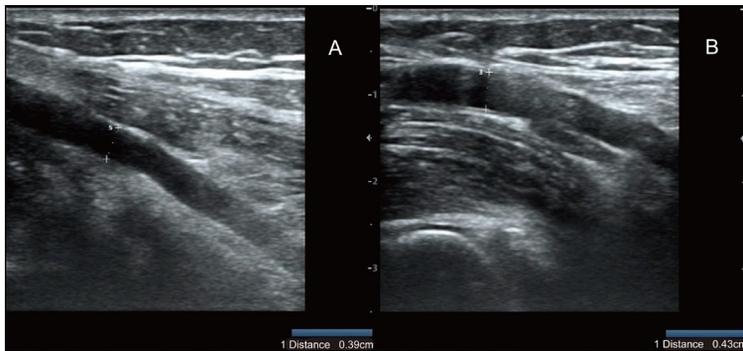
Typical Doppler images of the patient's brachial artery, with and without lymph node metastasis. (A) Doppler ultrasound image of the brachial artery in a patient without lymph node metastasis. The vessel appears normal, with no signs of abnormal flow or structural changes; (B) Doppler ultrasound image of the brachial artery in a patient with lymph node metastasis. Structural changes and altered blood flow are visible compared to the normal appearance in (A).
